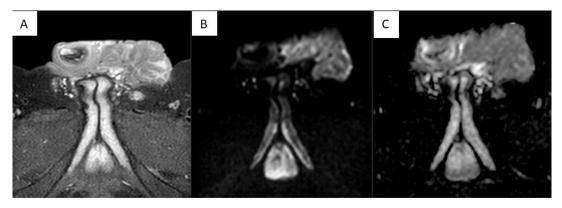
Pelvis MRI in axial slices showing heterogeneous contrast enhancement in fat-saturated T1 sequence (A) after injection of paramagnetic contrast medium with areas of restricted diffusion on high B-value of 1000 on DWI (B) and ADC (C) sequences
